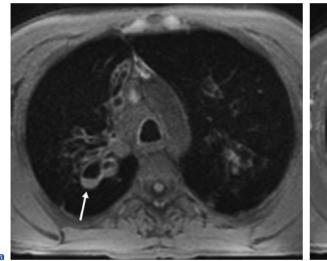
Transverse MR T2 weighted (HASTE) image (a) and corresponding CT image (b) of a 14 years old female with CF. In both images bronchial wall thickening, bronchiectasis, peripheral mucus plugging and dorsal consolidations are
